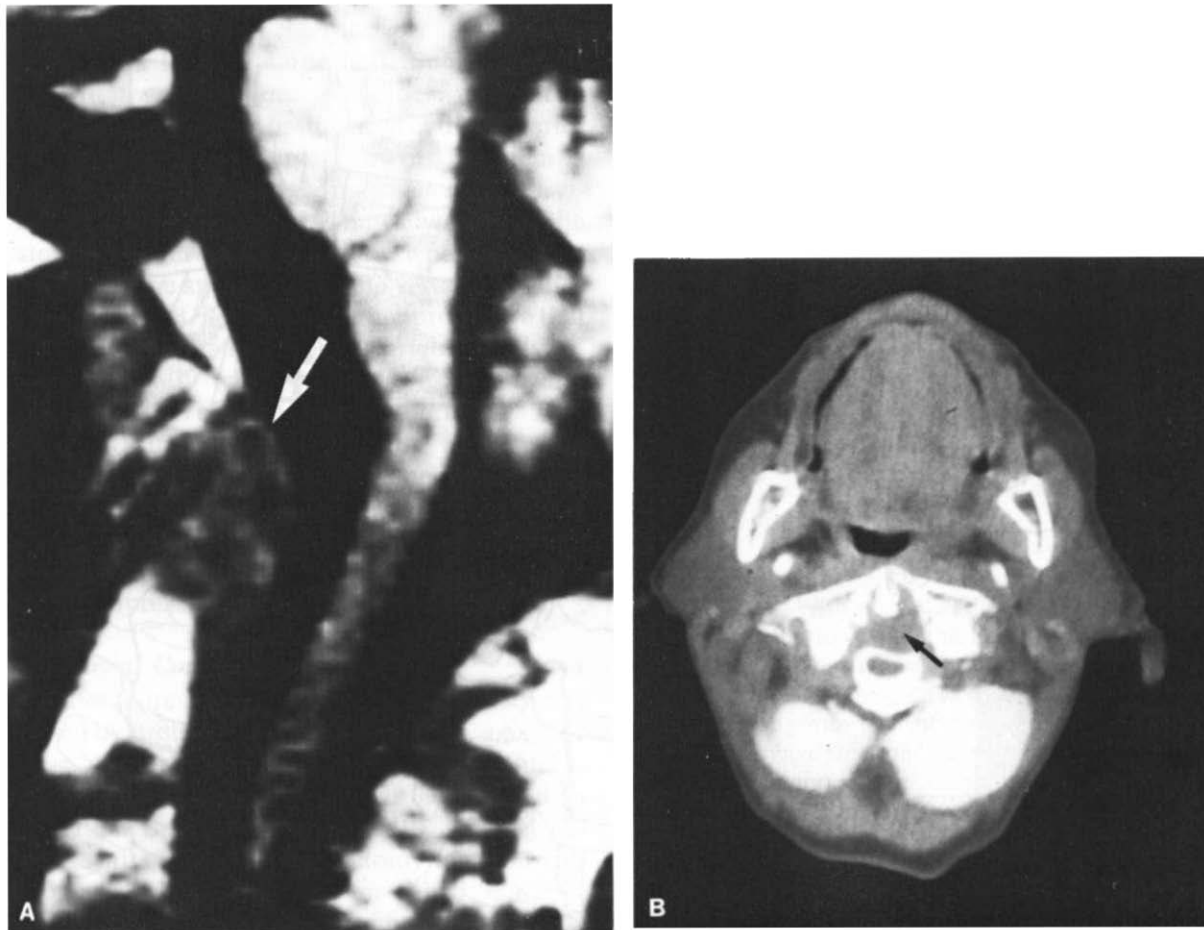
(A) This sagittal reconstruction of a CT scan at the level of the dens shows pannus (arrow) at and behind the dens pushing the spinal cord posteriorly. (B) This CT scan at approximately the same level shows effacement of the spinal cord by the pannus, which cannot be seen but is indicated by the arrow. (Courtesy of Charles Clark, M.D., and Joseph M. Mirra, M.D.)
